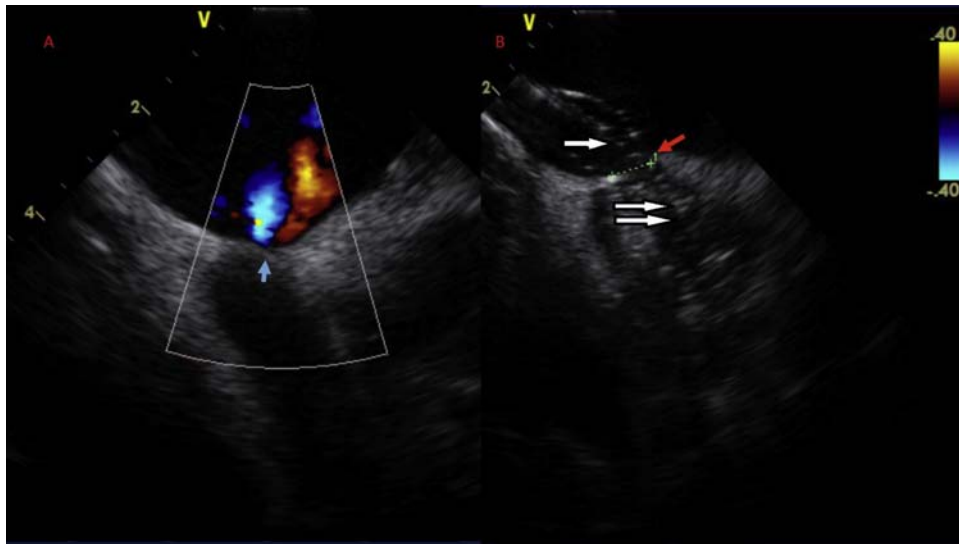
(A) Intracardiac echocardiography showing the presence of Doppler color flow across the PFO (*blue arrow*) and (B) the use of intracardiac echocardiography intraprocedurally for adequate balloon sizing of a PFO (*red arrow*) to determine the optimal septal occluder device size that should be used. The white arrow indicates the inflated balloon in the right atrium (*single arrow*) and left atrium (*double arrow*).
